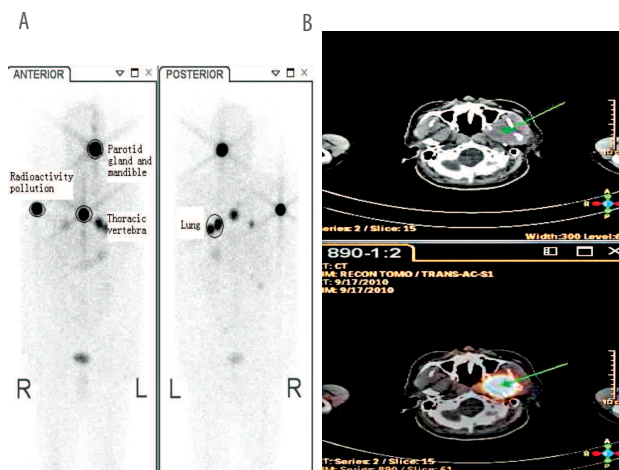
Post-therapy <sup>131</sup>I SPET/CT whole body scan (A) and transverse images (B).
